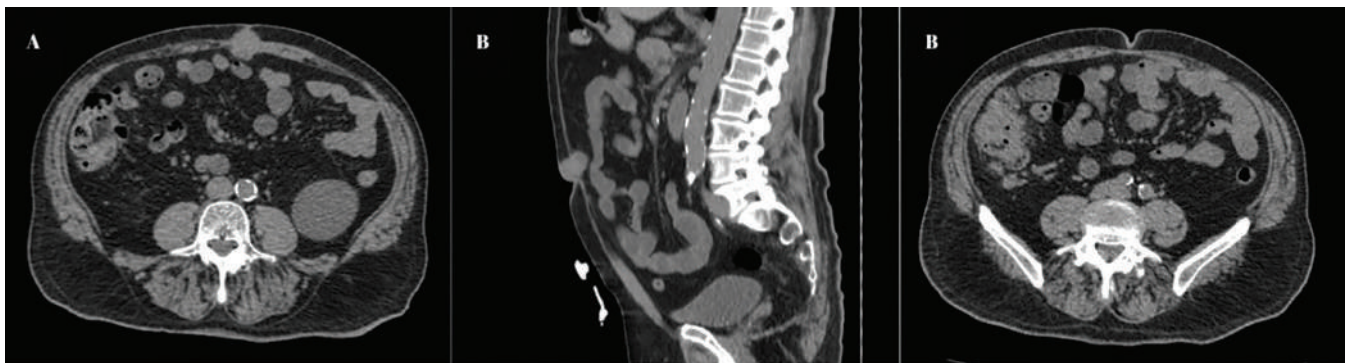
Contrast-enhanced abdominal computed tomography demonstrating (A) the primary cecal adenocarcinoma and (B) the isolated umbilical metastatic lesion consistent with Sister Mary Joseph's nodule.
